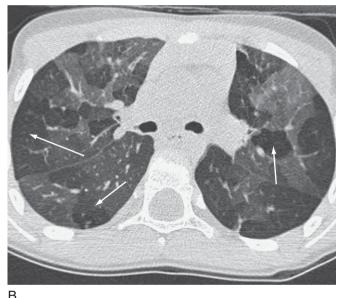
Utility of expiratory images in HRCT: 6-year-old girl with known cystic fibrosis. Image A was obtained during inspiration and is normal. Image B was obtained in expiration at the same level and demonstrates multiple regions of air trapping (*arrows*).
